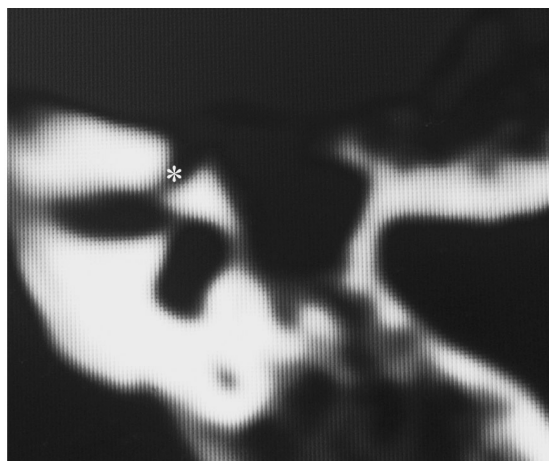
View of the LS of the FN (*) on the axial temporal bone HRCT scan before transmastoid decompression.
